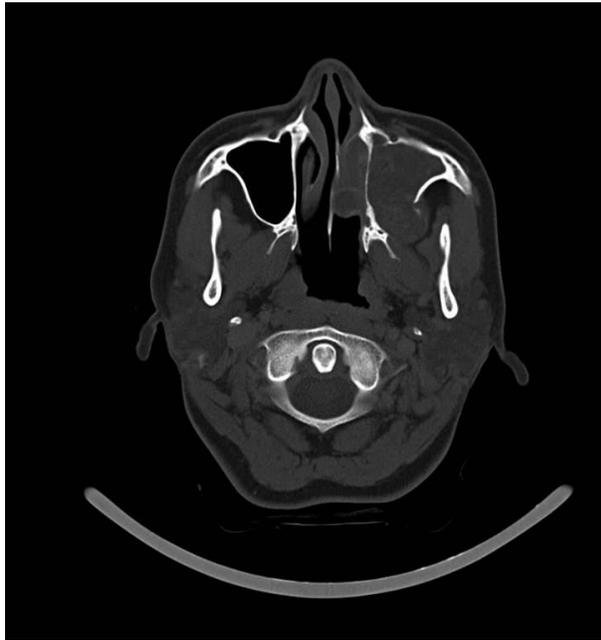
CT scan view of the lesion
